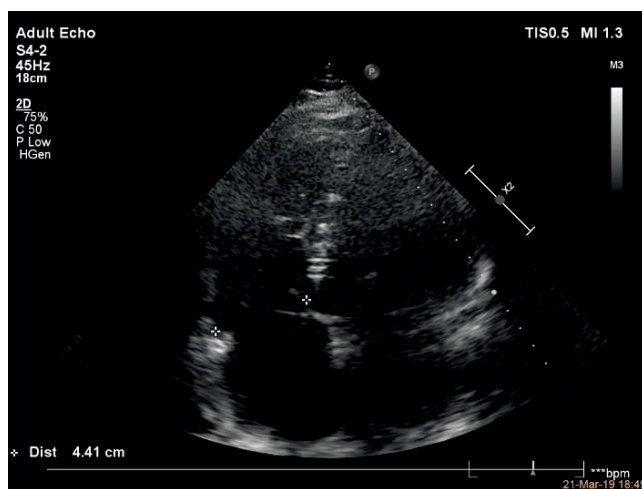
Transthoracic echocardiography, apical view, basal RV dimension 44 mm.
